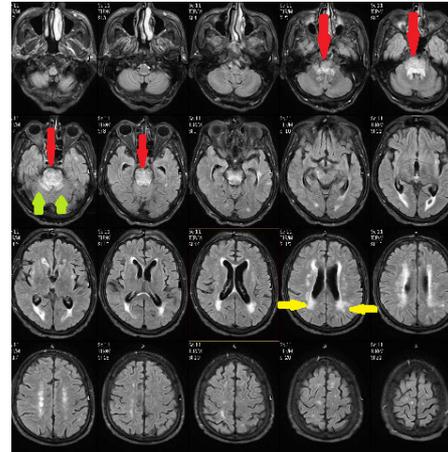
Central PRES – Axial FLAIR images showing hyperintense signal involving brainstem (red arrow) and cerebellar hemisphere (blue arrow). In a patient receiving chemotherapy. In addition extensive chronic white matter ischemic foci are seen (yellow arrow).
